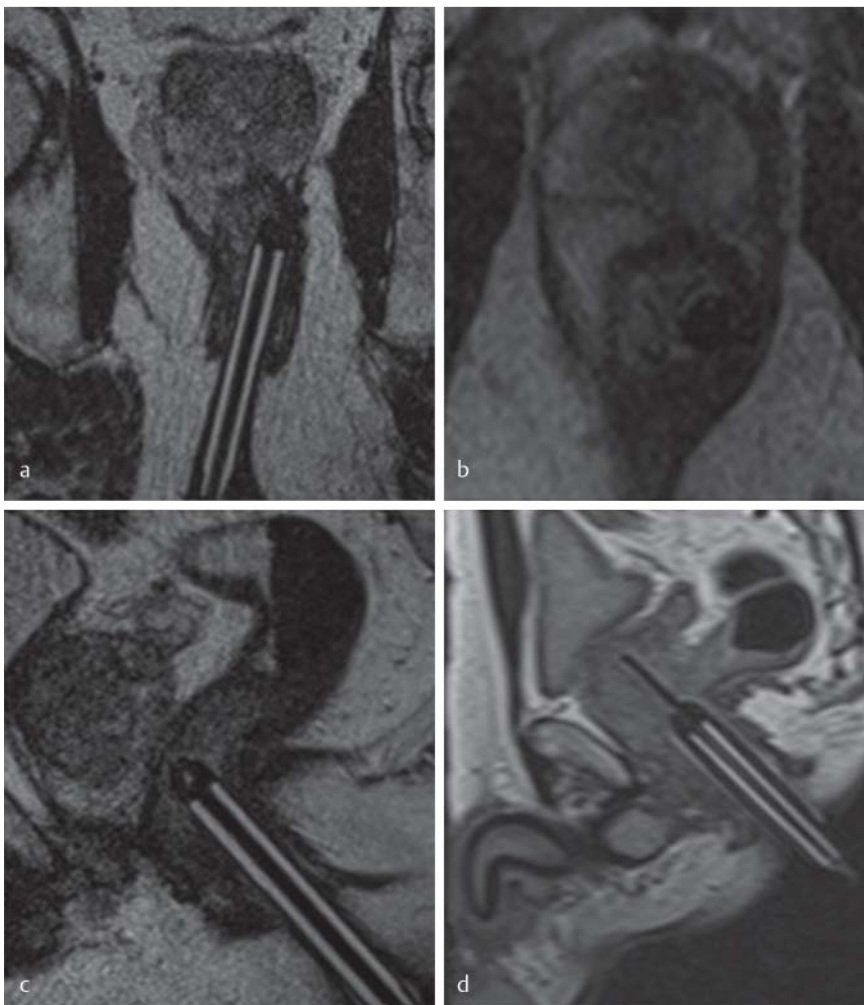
MRGB of the prostate from the patient shown in Fig. 1. a Coronal, b axial and c sagittal T2-weighted images after insertion of the needle guide in the rectum. Pathology confirmed a PCa with a Gleason score of 7 (4 + 3) in the lesion in the peripheral zone. d Kontrollscan with the MRI compatible biopsy needle.
